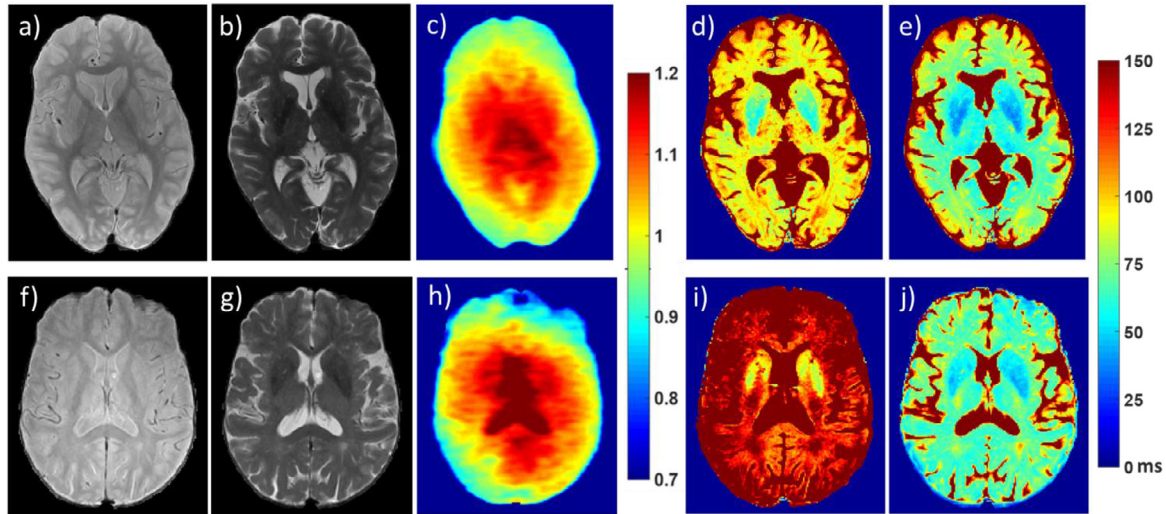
Example images and resultant maps from two ADNI-1 subjects. Top Row: 77 yr healthy female from vendor 1 using a refocusing flip train of 165°–150°–150°.... Bottom Row: 78 yr healthy female from vendor 2 using a refocusing flip train of constant 125°. The input PD-weighted (a, f) and T2-weighted (b, g) images are shown along with estimated nB1⁺ maps (c, h). T2 maps (ms) computed using exponential method (d, i) and Bloch based fit method (e, j) show the disparity in T2s between subject/vendor with the exponential approach but similarity with the Bloch method.
